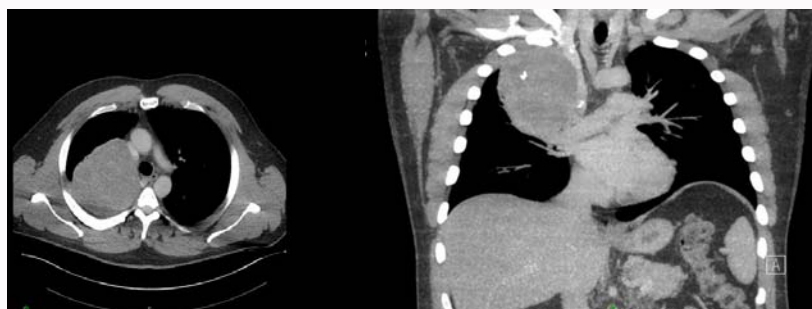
CT Chest—axial and coronal images.
